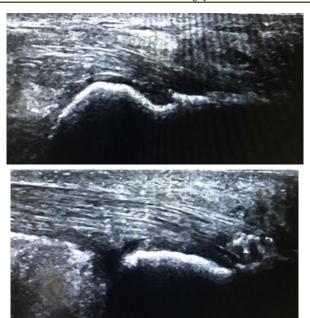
Ankle ultrasound: Pre-achilles bursitis (blue arrow) with cracked achilles tendon (arrow)
